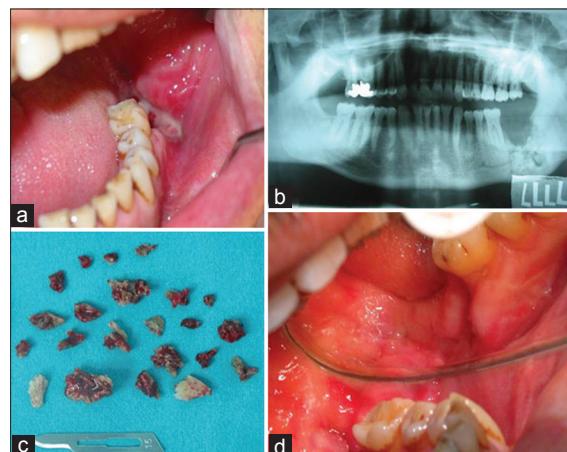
(a) Bone necrosis of the left posterior mandible. (b) Radiographic view. (c) Removed necrotic bone. (d) Post-surgical view.
